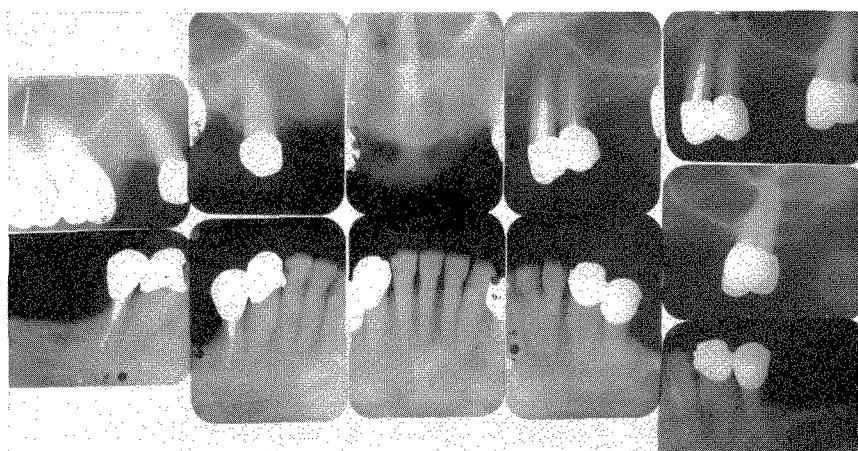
In 1954 the left abutment became more mobile, and a two-unit splint was constructed as shown in the roentgenograms.
